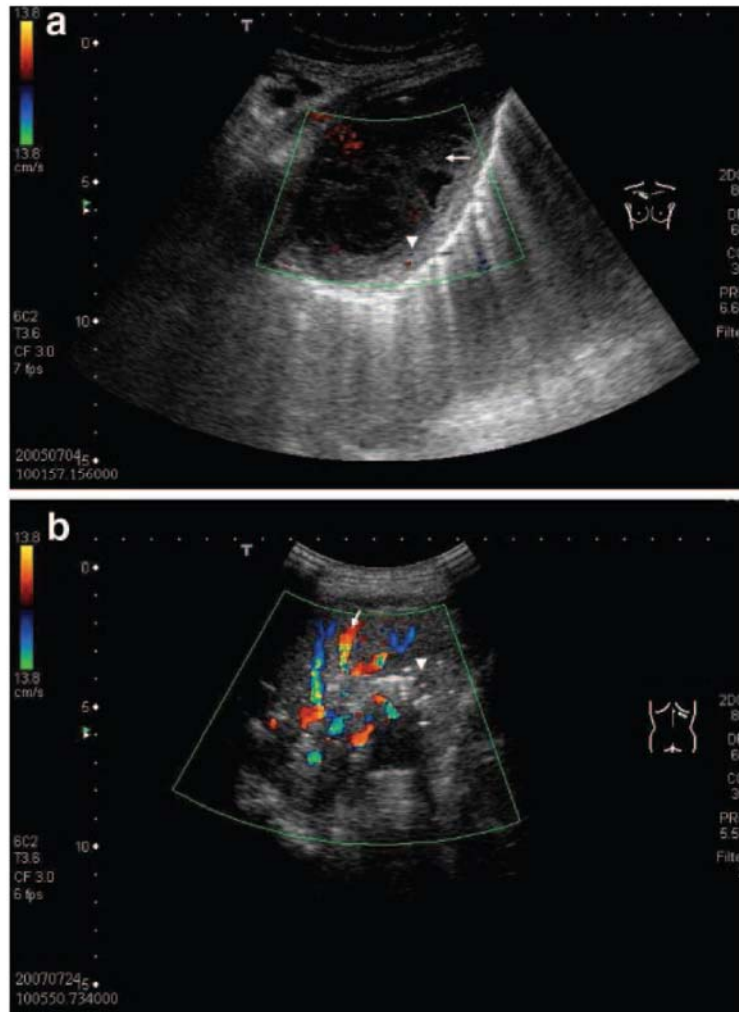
Top, a:* empyema. A 32-year-old man had an empyema in the right upper lobe. Ultrasound examination of the chest revealed a hypoechoic lesion with complex-septated effusions (arrow), passive atelectasis (arrowhead), width uniformity, and smooth luminal and outer margins. Color Doppler ultrasound could not identify vessel signals in pericavitary atelectasis. *Bottom, b:* abscess. A 64-year-old man had an abscess in the right lower lobe. Ultrasound examination of the chest revealed a hypoechoic lesion with typical pulmonary consolidation (characterized by tree-shaped air bronchogram with ramifications) [arrowhead], irregular wall width, and irregular luminal and outer margins. Color Doppler ultrasound could identify vessel signals in pericavitary consolidation (arrow).
